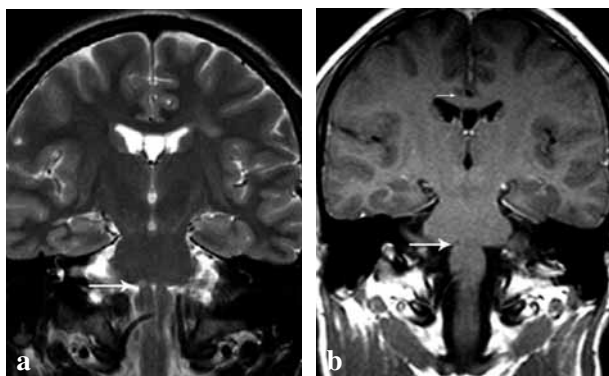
Patient 9, brain MRI: (a) T2 weighted sequences showing multiple white matter hyperintensities, one of which is located in the pons on the right side, responsible for the symptoms (arrow); (b) T1 weighted sequence after gadolinium enhancement showing that the pontine lesion is hypointense, with no post-contrast enhancement (arrow).
